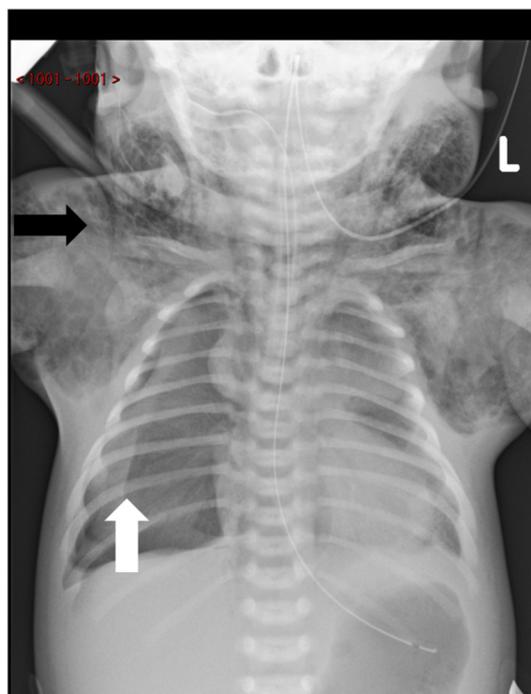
Chest X-ray showing mediastinal air, subcutaneous emphysema (black arrow) and pneumothorax (white arrow).
